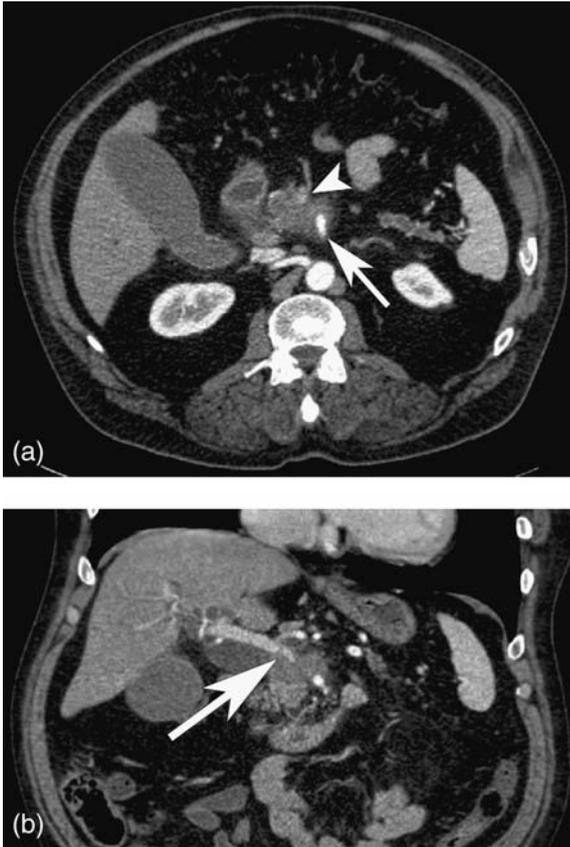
A spiral CT scan of a patient with pancreatic cancer with encasement of (a) portal vein (coronal) (arrowhead) and mesenteric artery (arrow) and (b) the portal vein (axial) (arrow).
